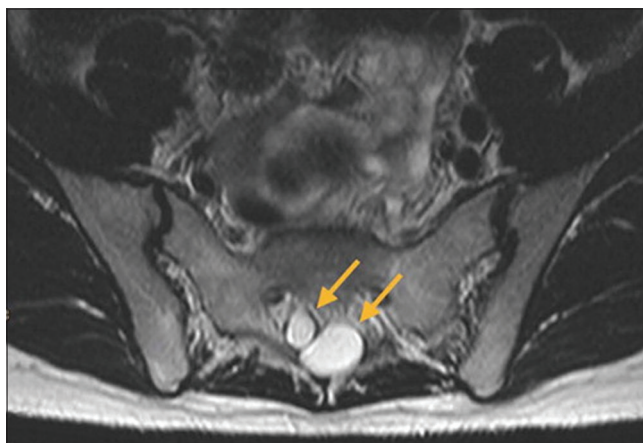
Axial T2-weighted magnetic resonance imaging of the lumbosacral spine revealing perineural (Tarlov) cysts (arrows) at the level of S2.
